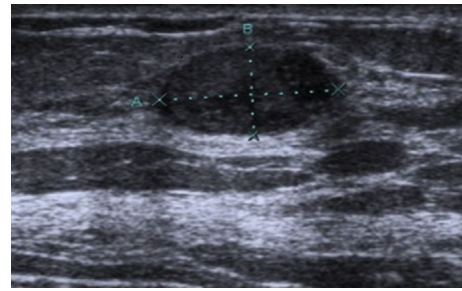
A solid mass lesion with ultrasound appearances of a typical fibroadenoma negating the need for needle biopsy.
